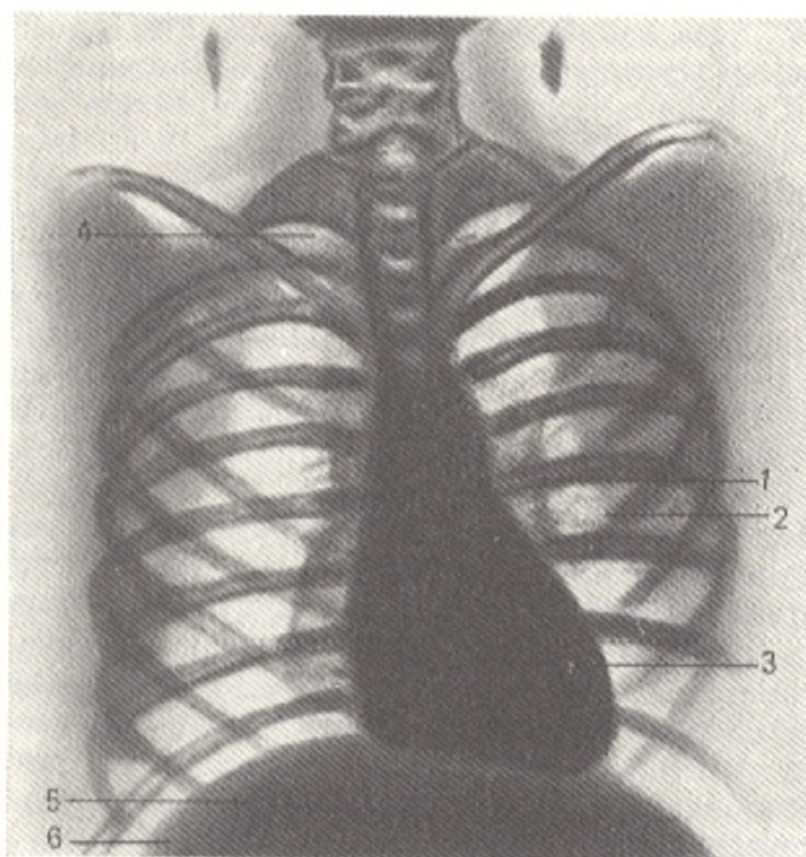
Radiograph of thoracic cage.
